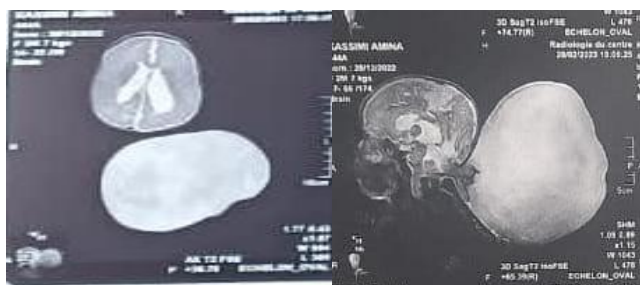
Radiological aspect of the occipital encephalocele, sagittal and axial sections of MRI of the brain.
